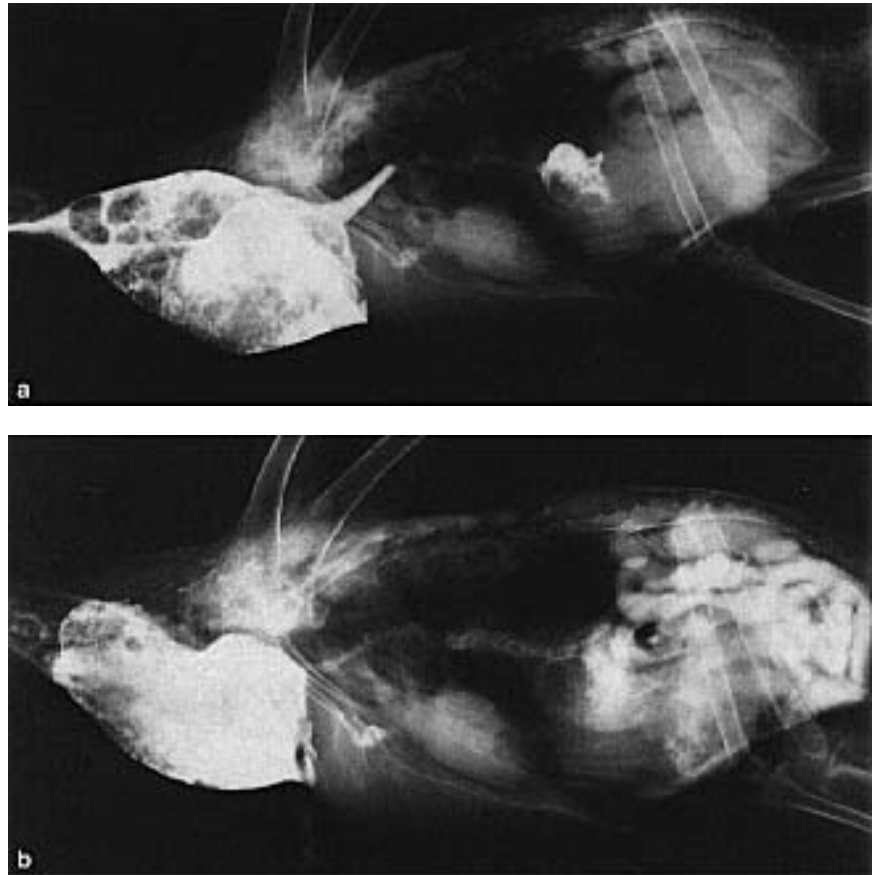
A mature Umbrella Cockatoo was presented with a history of progressive weight loss of one month's duration. The bird had been vomiting for a week before presentation. Survey radiographs indicated a thickened proventriculus. Contrast medium was instilled into the crop and indicated a thickened proventricular mucosa and slowed gastric emptying time: a) at 20 minutes; b) at six hours. Note the small heart (suggestive of severe dehydration) and microhepatia. The client chose euthanasia. At necropsy, the proventricular mucosa was ulcerated and inflamed and had numerous nodules. *Spiroptera* eggs were identified in proventricular washings.
